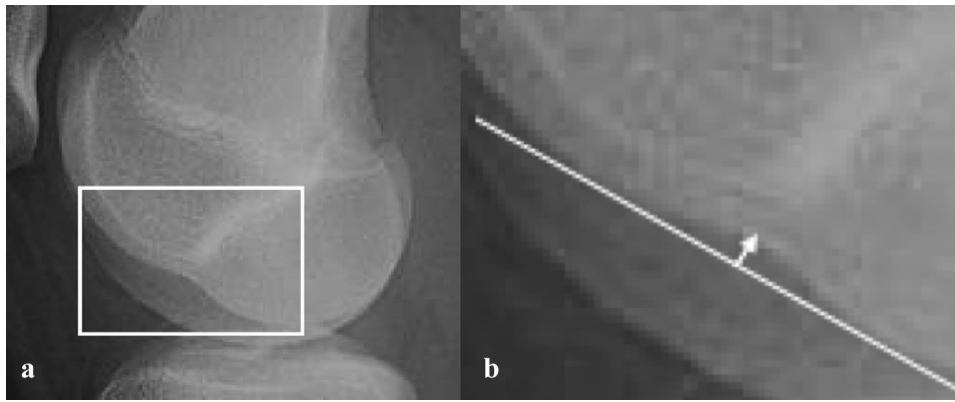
Method of measuring the lateral femoral notch (LFN) on plain radiographs. a A high quality lateral radiograph without malrotation must be obtained. Example shown here. b Magnification of area outlined in (a). A line is then drawn tangential to the articular surface of the lateral femoral condyle, across the lateral femoral notch (or
